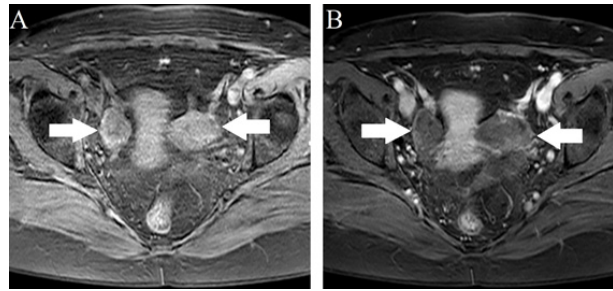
MRI in axial section, T1 FAT SAT sequence, non-enhanced (A) and enhanced (B) images, showing enlarged ovaries with fibrous thickening of their margins, trapping follicles, with heterogeneous contrast enhancement (white arrows), compatible with bilateral ovarian fibromatosis.
